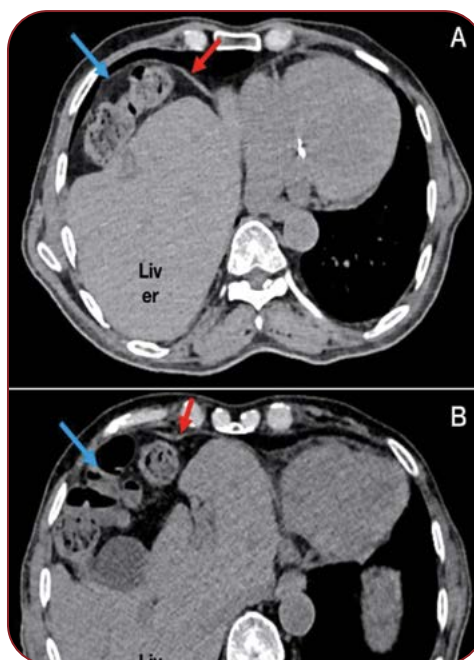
Case 3 computed tomography abdomen, axial views (A, B), showing colonic hepato-diaphragmatic interposition (blue arrows) with elevation of the right diaphragmatic dome/eventration (red arrows).
